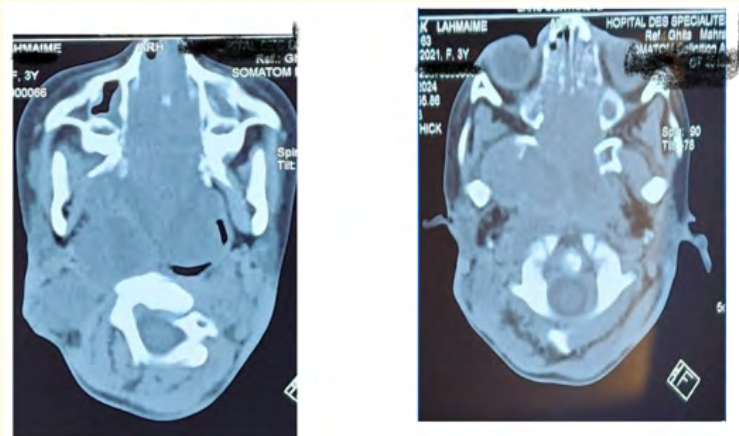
Non-contrast cervicofacial CT scan showing an expansive nasopharyngeal mass with extensive locoregional invasion and multiple bilateral lateral cervical lymphadenopathies.
